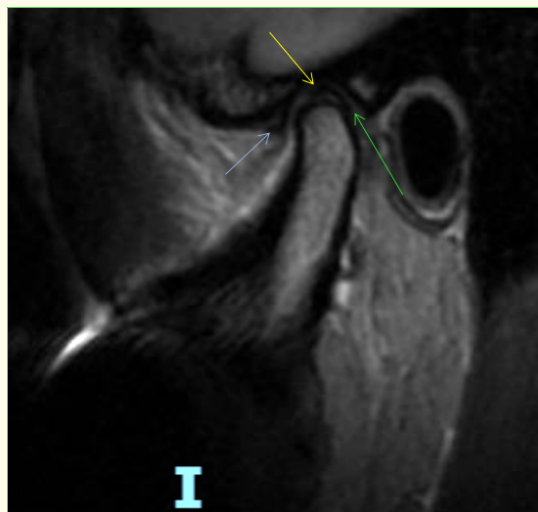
MRI of the right TMJ on sagittal view. Articular (adaptive) pseudo-disc on right TMJ is shown. *Yellow arrow:* anterior-superior limit of the pseudo-disc (adapted retrodiscal zone), due to an important anterior-medial articular disc displacement. *Green arrow:* posterior-inferior limit of the adaptative disc (pseudo-disc). *Blue arrow:* anterior band of the (real) articular disc.
